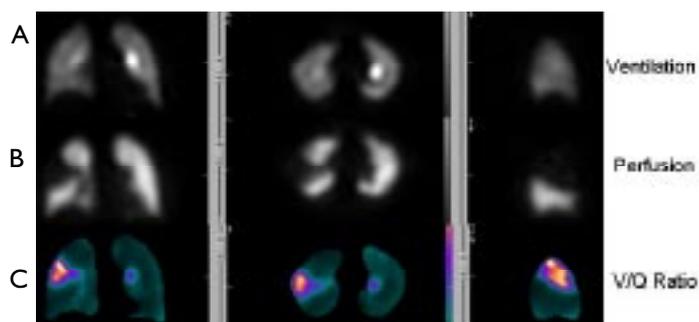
(A) Ventilation SPECT showing uniform distribution of Technegas throughout lung fields. (B) Multiple areas of perfusion reduction identified. (C) V/Q Ratio images confirming areas of mismatch identified on V/Q SPECT.
